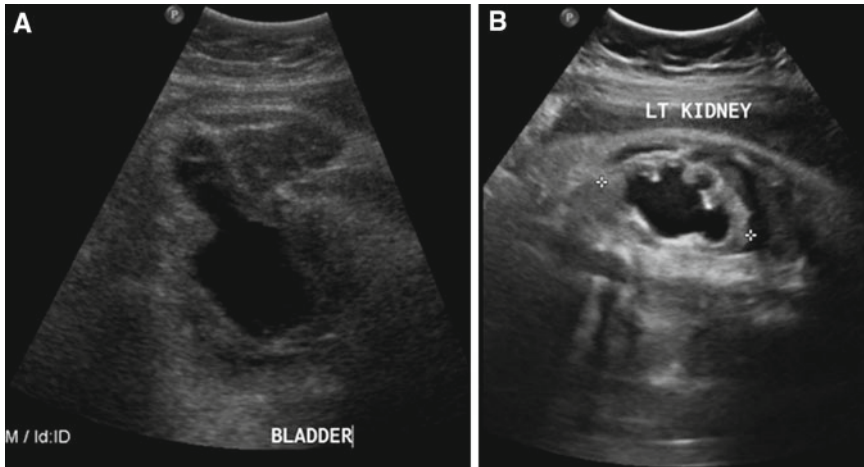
Sonographic features suggestive of PUVs detected during antenatal evaluation: (a) thick-walled bladder with prominent posterior urethra, the “key-hole” sign; (b) high-grade hydronephrosis
